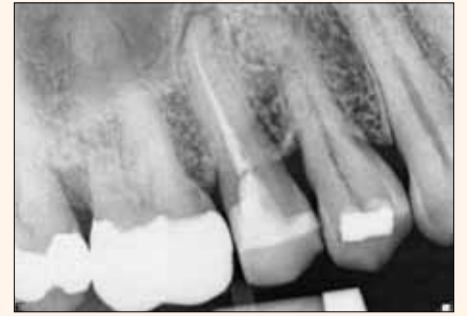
Periapical showing a normal fill with a radiolucency.
